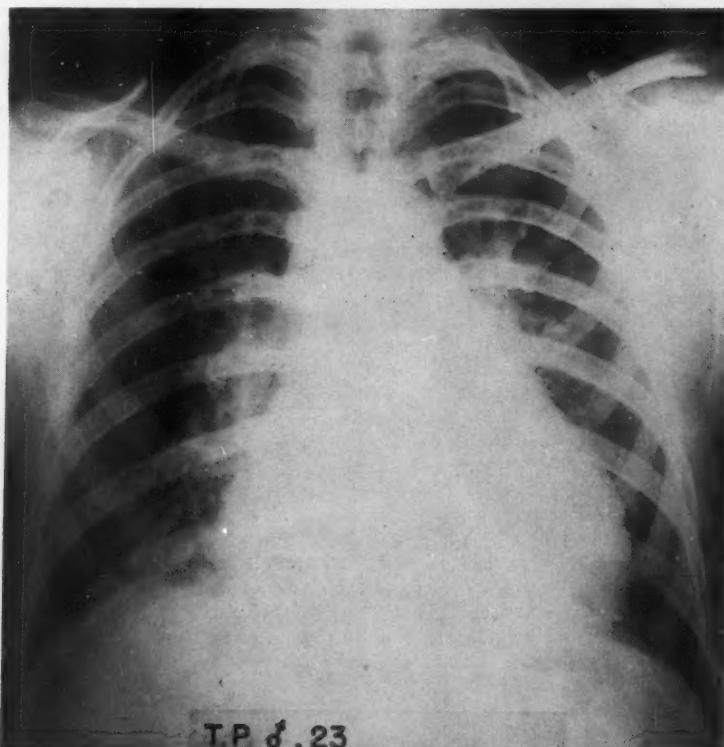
Chest x-ray taken at the time of operation, showing general enlargement of the heart with prominence of the left atrium.
